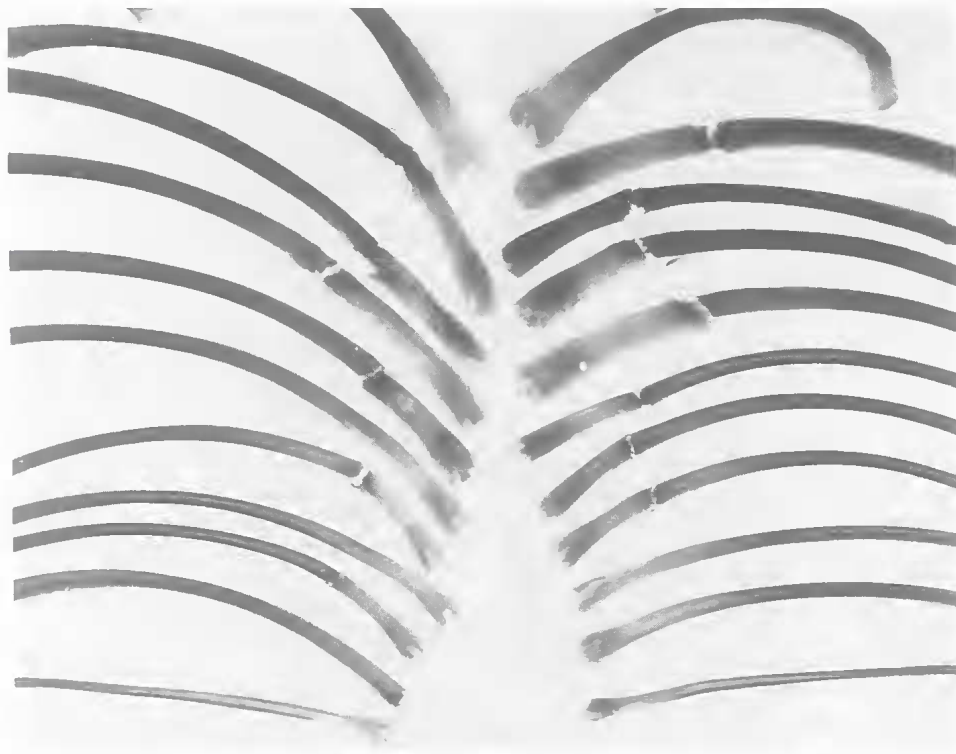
Minke whale QMJM7301. Radiograph demonstrating numerous bilateral ventral rib fractures. The sternum has not been included.
